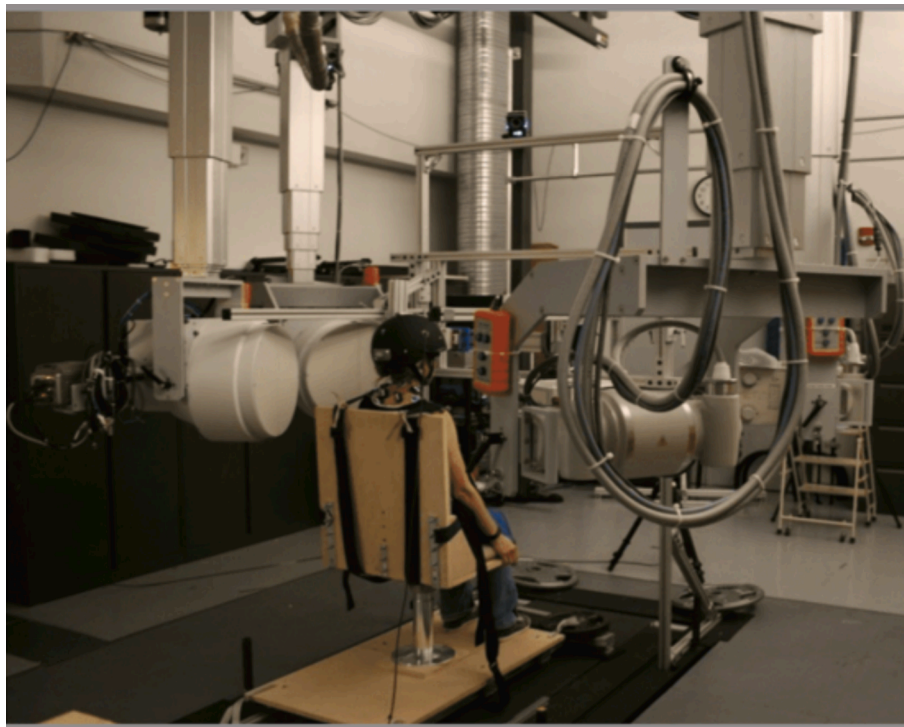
Experimental setup consisting of height-adjustable chair, dynamic radiographic imaging system, Vicon surface-markers, and Vicon motion analysis system. Adapted from Zhou et al., 2020.
